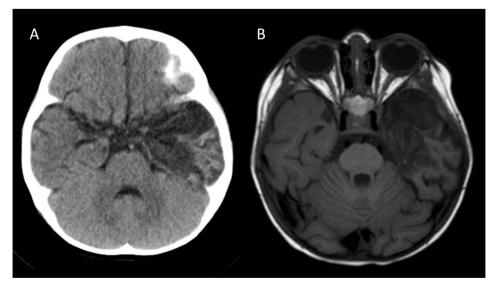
CT scan (day 20, A) and MRI (day 30, B) showing focal necrosis mainly affecting the left temporal lobe consistent with herpes simplex encephalitis.
